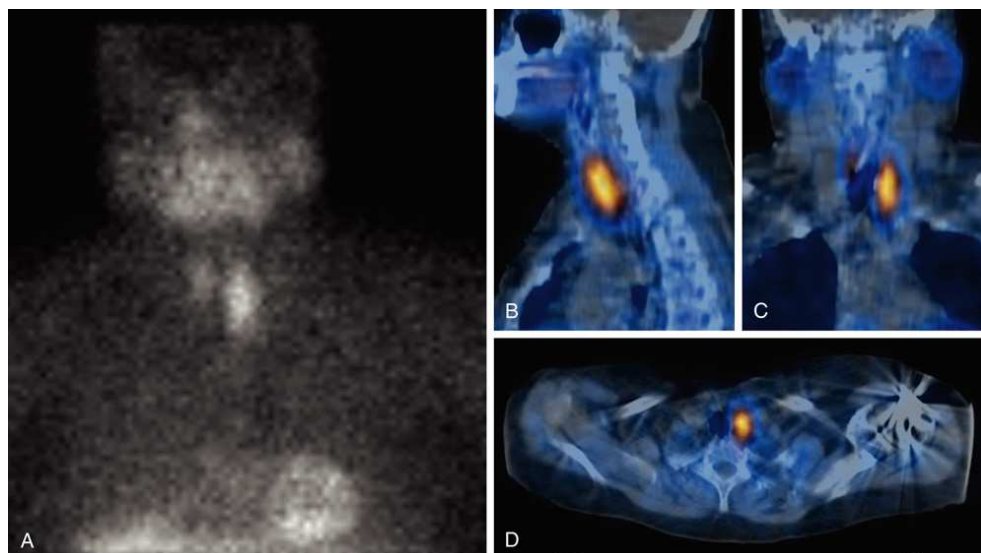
^{99m}Tc Parathyroid SPECT/CT fused imaging. Increased uptake/activity in the left lower lobe. Results are indicative of an adenoma. (A) A 60-minute static delay of the neck and chest (tracer activity only). (B) Sagittal plane (SPECT/CT fused imaging). (C) Coronal plane (SPECT/CT fused imaging). (D) Axial plane (SPECT/CT fused imaging).
